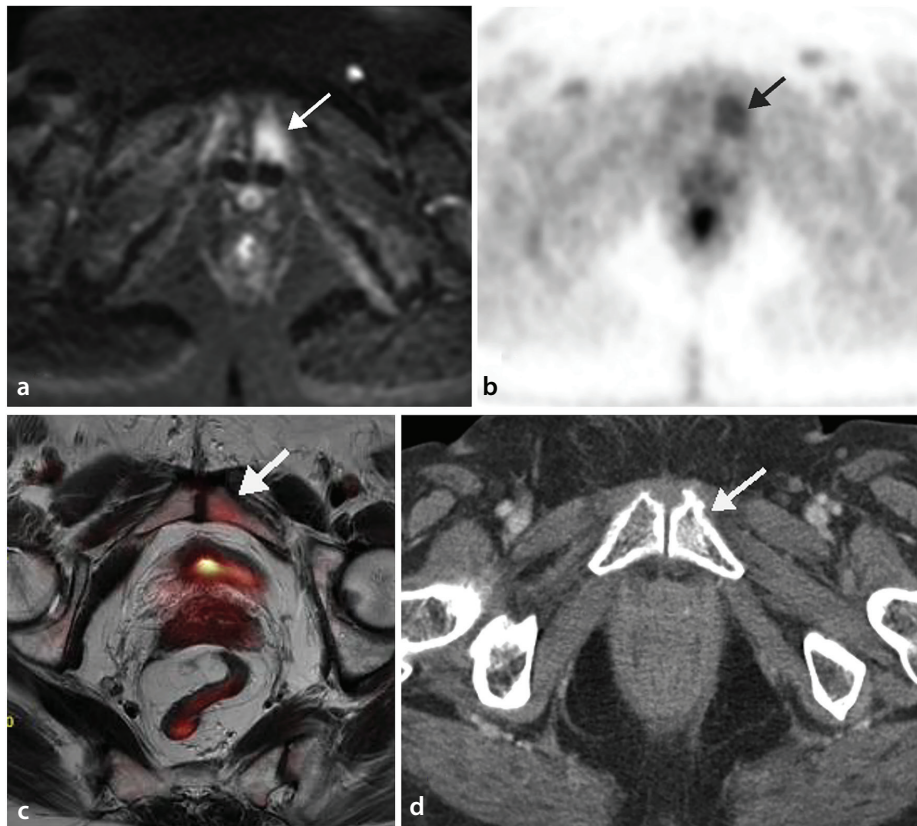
Osteitis pubis. The axial diffusion-weighted magnetic resonance image (MRI) (a) shows diffusion restriction (arrow) at the left side of the pubic symphysis. The axial positron emission tomography (PET) (b) and axial fused PET/MRI (c) show moderate unilateral fluorodeoxyglucose uptake (arrows) adjacent to the pubic symphysis. On the computed tomography (d) image, mild subchondral sclerosis associated with cortical irregularity (arrow) supports the diagnosis.
